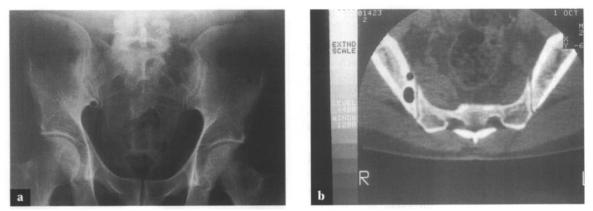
Bone cysts: causing bone pain during descent and/or ascent. (a) X-ray of pelvis: a rounded translucency is seen in the right ilium adjacent to the lower part of the right sacroiliac joint. (b) Computed tomography scan: two rounded air bubbles are seen in the right ilium. One lies anteriorly in the cortex, and the other lies within the medulla. (Courtesy of Dr B.L. Hart.)
